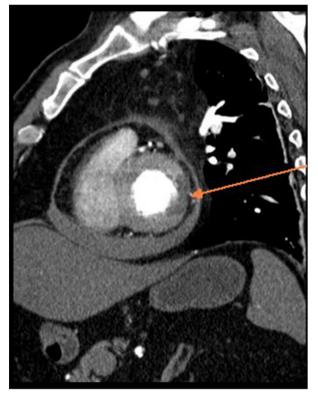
CT scan showing change in lateral wall contrast perfusion concerning for possible ischemia/infarct.
